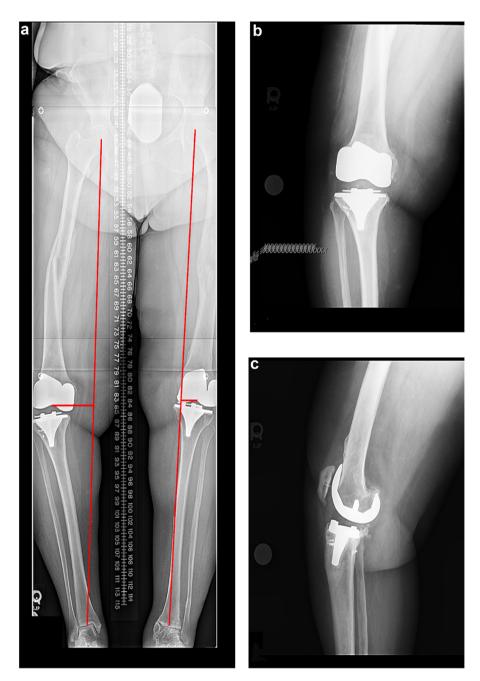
Radiographs of a failing, symptomatic right total knee arthroplasty in the setting of uncorrected extra-articular deformity. Standing hip-to-ankle radiographs demonstrate genu varum with a mid-diaphyseal femur deformity (a). Note the incongruent joint line and knee subluxation on the anteroposterior (AP) (b) and lateral (c) views.
